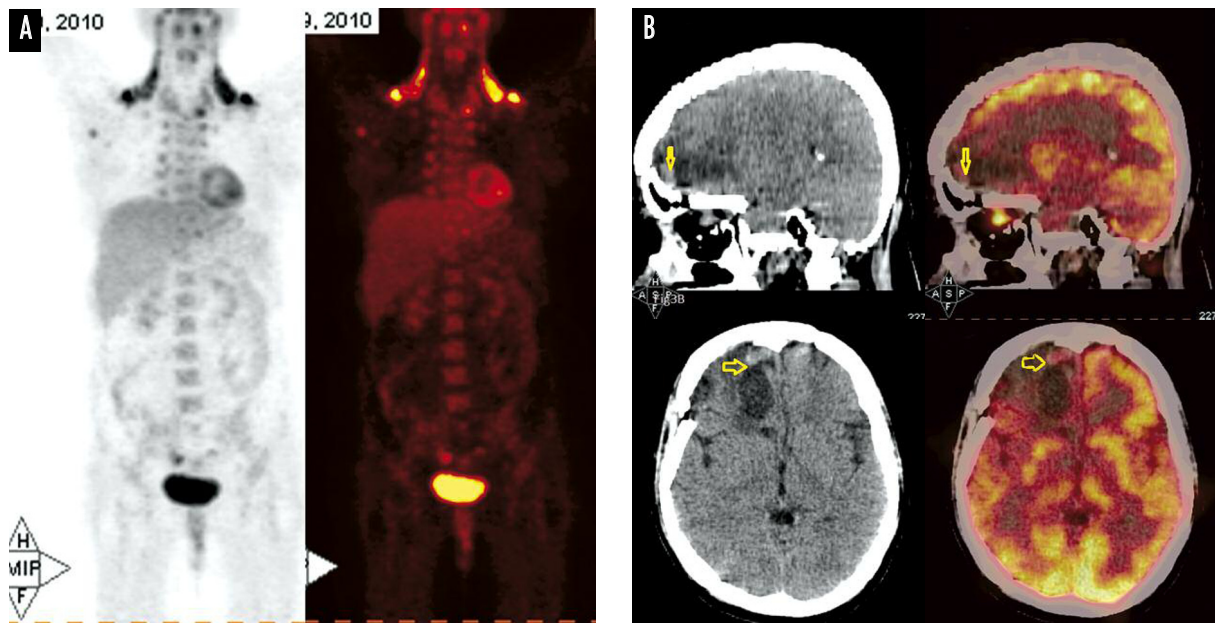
(A) Whole body 18F-fluorodeoxyglucose (FDG) PET-CT scan shows no evidence of extracranial primary lesion. (B) Postoperative cavity in the right frontal lobe with residuum in the right basifrontal region showing mild FDG uptake (arrow)
